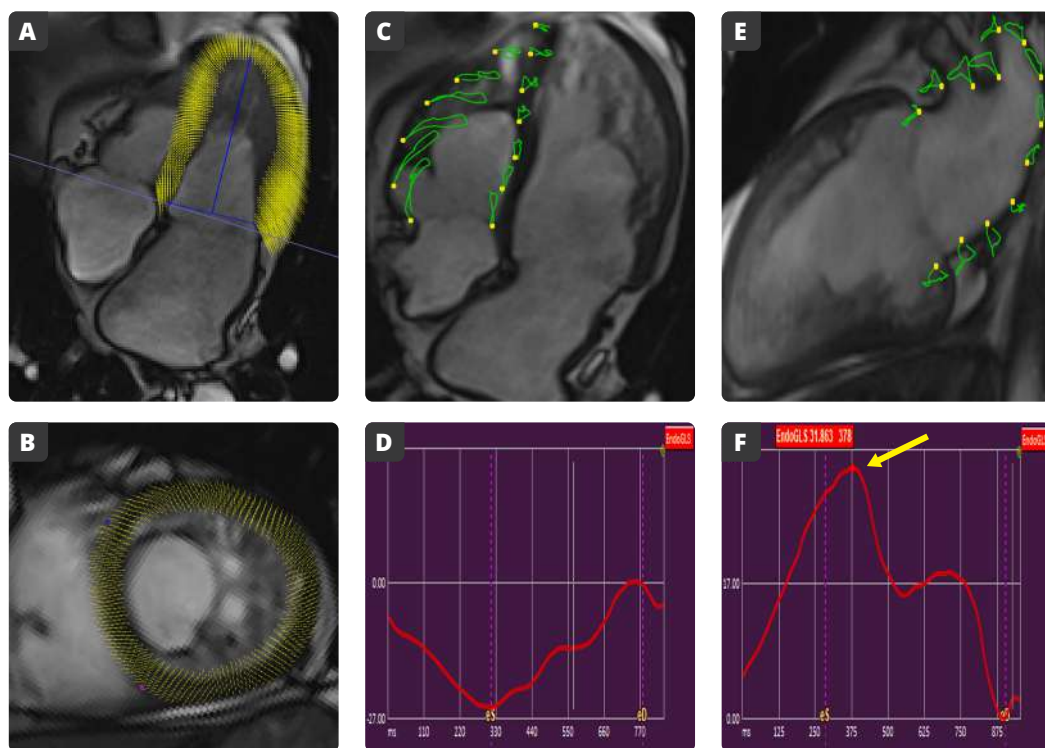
Valoración de los parámetros de deformación miocárdica o *strain*. Contornos del ventrículo izquierdo en A) eje apical 4 cámaras y B) eje corto. C) Contornos del ventrículo derecho. D) Curva de *strain* longitudinal global del ventrículo derecho. E) Contornos de la aurícula izquierda. F) Curva de *strain* longitudinal global de la aurícula izquierda; la flecha amarilla señala el *strain* reservorio.
